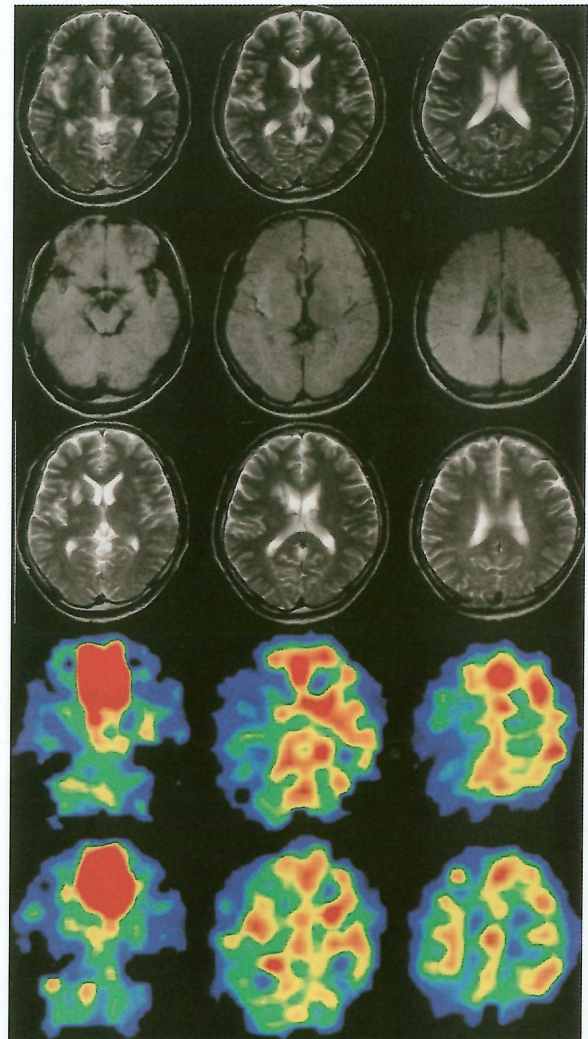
MRI and Xe-SPECT; T2WI and DWI on admission, T2WI at discharge, 133Xe-SPECT pre-fibrinolysis and post fibrinolysis.
